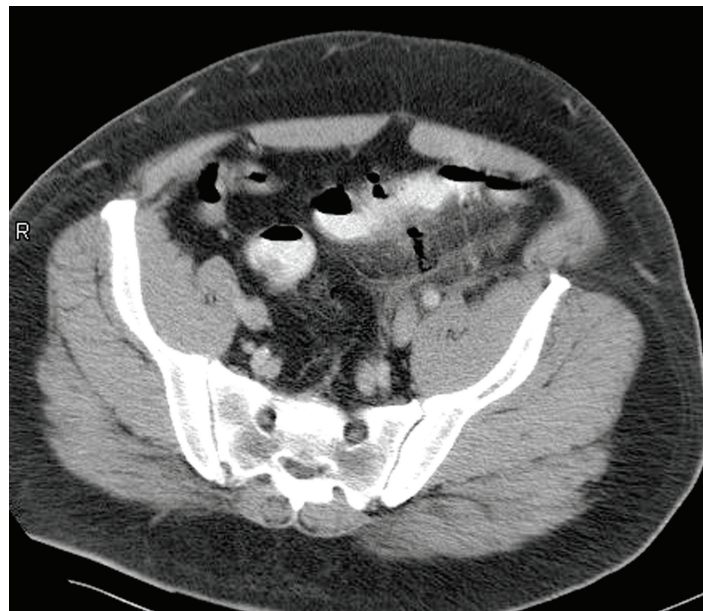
CT Scan Diverticulitis of Sigmoid Colon
